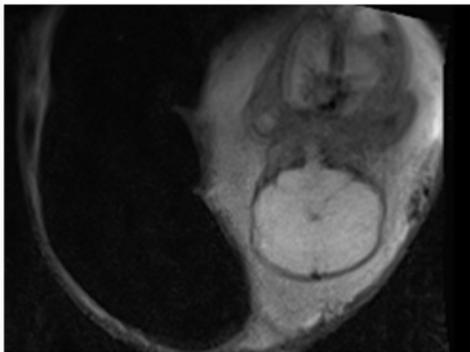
MRI of the abdomen and pelvis. Marked dilated colon with impacted fecal matter noted in the right abdominal side. Fetal cephalic presentation displaced in the left pelvic side.
